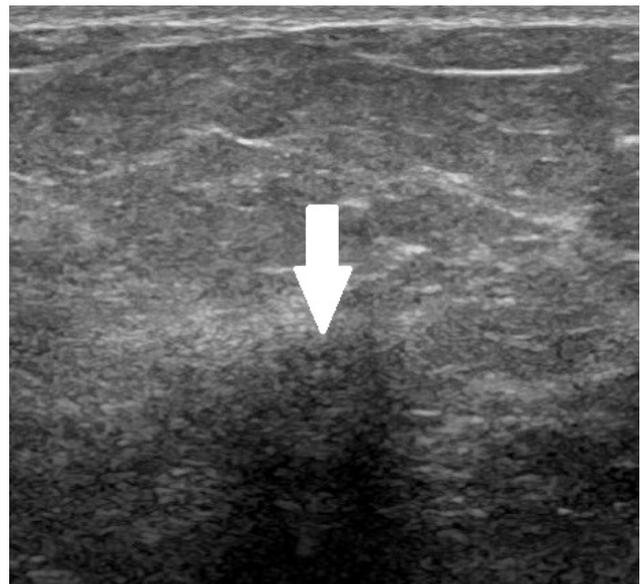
Ultrasound image of a RS demonstrating a 1.5cm, irregular, hypoechoic mass with posterior shadowing (arrow)
